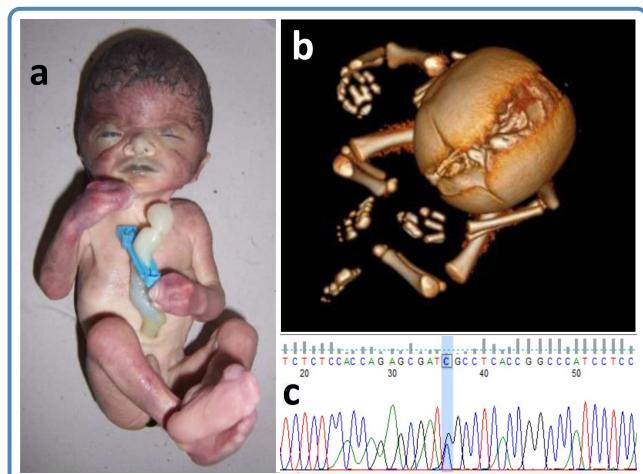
[a] A fetus with Apert syndrome showing tower skull and syndactyly [b] CT scan of the head showing closed coronal sutures and wide open sagittal suture [c] Sequencing results of a part of *FGFR2* gene showing the p.Ser252Trp mutation.
